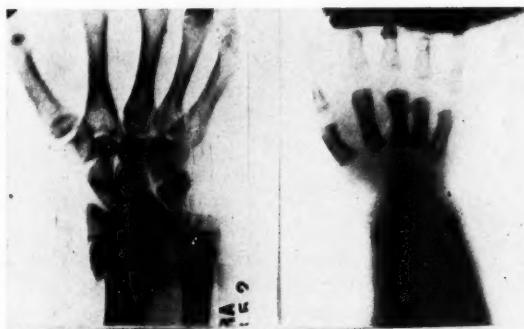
Retarded bone age characteristic of juvenile myxedema. *Left:* Normal child—chronological age, 12 years; x-ray bone age, 12 years. Note all carpal bones present. *Right:* Childhood myxedema—chronological age, 12 years 2 months; x-ray bone age, 6 months to 1 year. Note only two carpal bones present. (Through the courtesy of Dr. C. Kelly Canelo, San José, California.)
